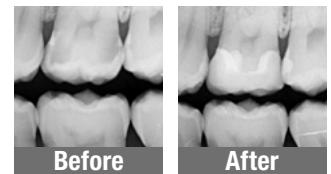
X-ray image before and after the surgery
